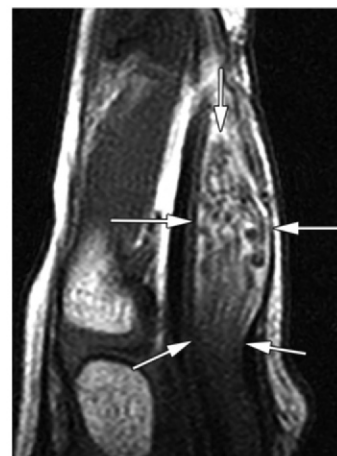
Lipomatosis of the median nerve in an 8-year-old boy with a mass of the right hand. Axial (a), coronal (b), and sagittal (c) T1-weighted MR images of the right hand show marked enlargement of the median nerve (arrows) with fat infiltration between tubular-appearing nerve fascicles, consistent with median nerve lipomatosis.
